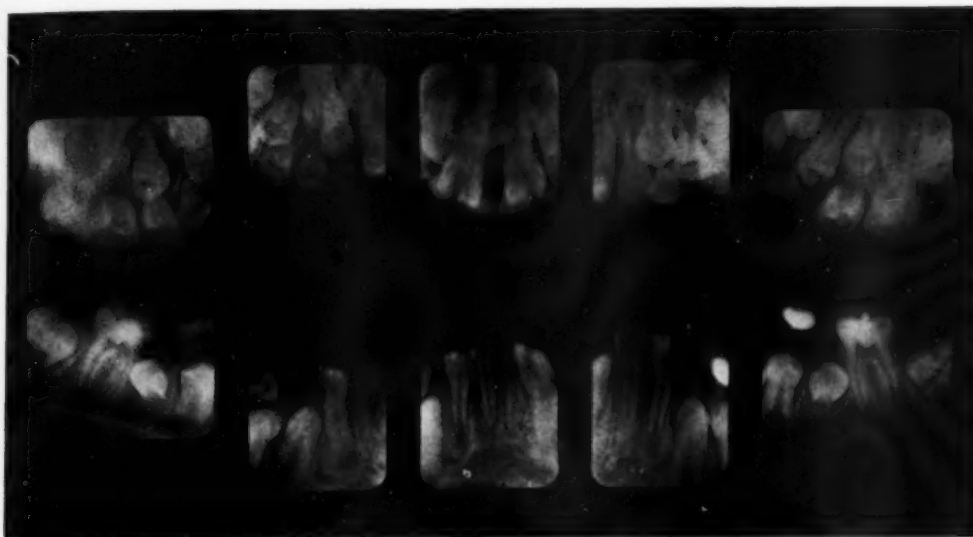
Hypothyroidism (cretinism). Dental roentgenograms of a girl thirteen and a half years of age. Development and eruption of the teeth correspond approximately to those of a child aged six to seven years. (Reproduced, with permission, from Stafne, E. C.: *Dental Roentgenologic Aspects of Systemic Disease*. J. Am. Dent. A. 40: 265-283, March 1950.)
